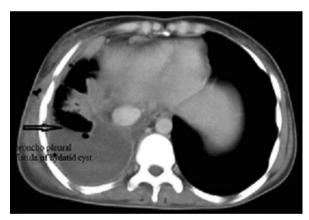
Abdominal CT revealed right bronchopleural fistula.
